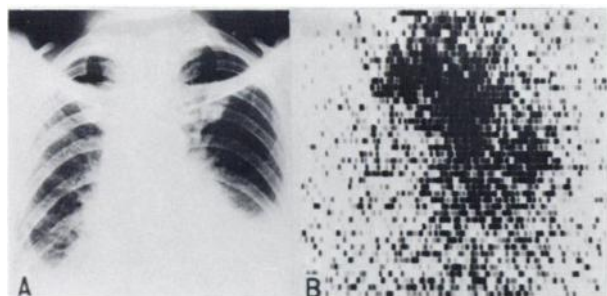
(A) Chest x-ray shows hydrothorax bilaterally but can not detect metastasis in mediastinum precisely. (B) Scintigram shows positive in upper part of right hilus, mediastinal center, and inside left lower lung as autopsy revealed.
